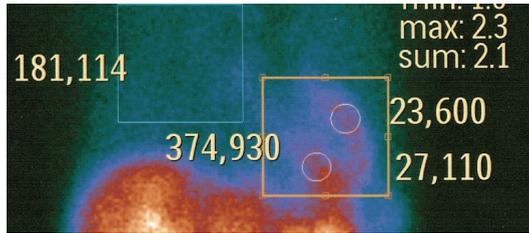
SPECT image acquired 5 minutes post stress with regions of interest including the total heart, anterior and inferior myocardial regions
